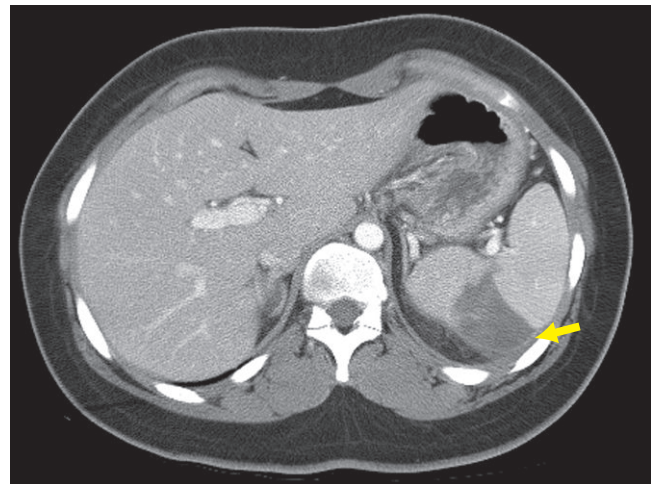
Corresponding CT demonstrating splenic laceration (arrow).
